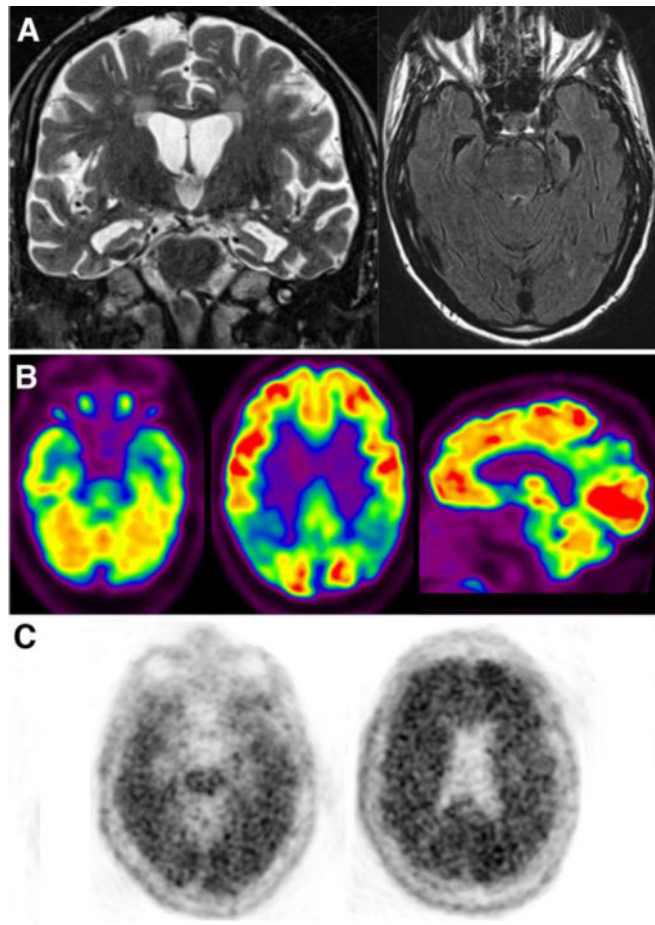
Neuroimaging in AD. (A) Coronal T2 and axial FLAIR MRI images show marked medial temporal lobe atrophy involving hippocampus and subjacent entorhinal cortex, out of proportion to global volume loss. (B) Axial and sagittal images from an ^{18}F -FDG PET shows typical lateral temporoparietal, posterior cingulate, and medial temporal lobe hypometabolism. Milder frontal hypometabolism is present, also common. (C) Axial images from a positive amyloid PET scan with ^{18}F -florbetapir showing diffuse cortical activity with loss of the distinction between gray and white matter.
